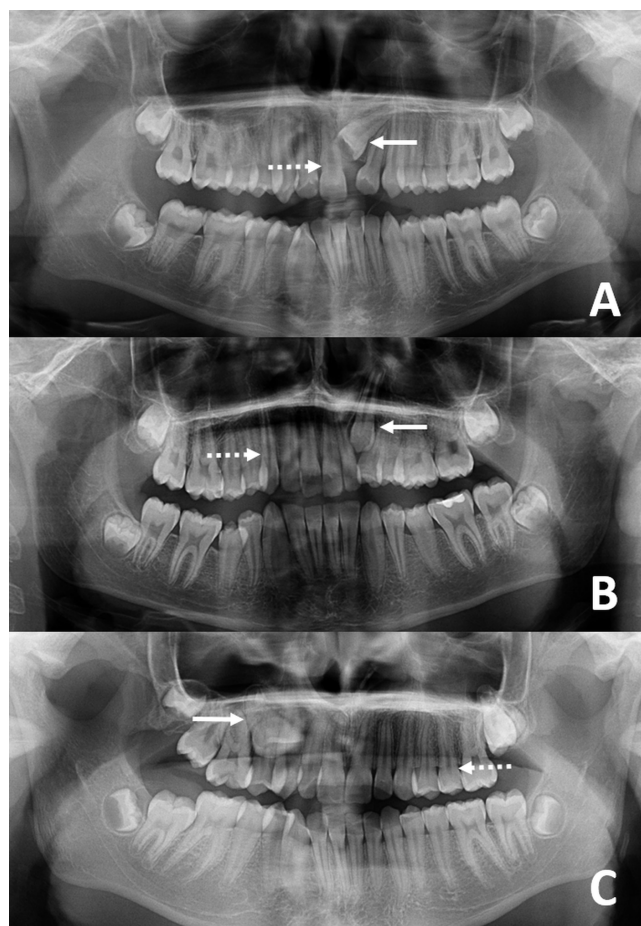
Results of panoramic radiography
